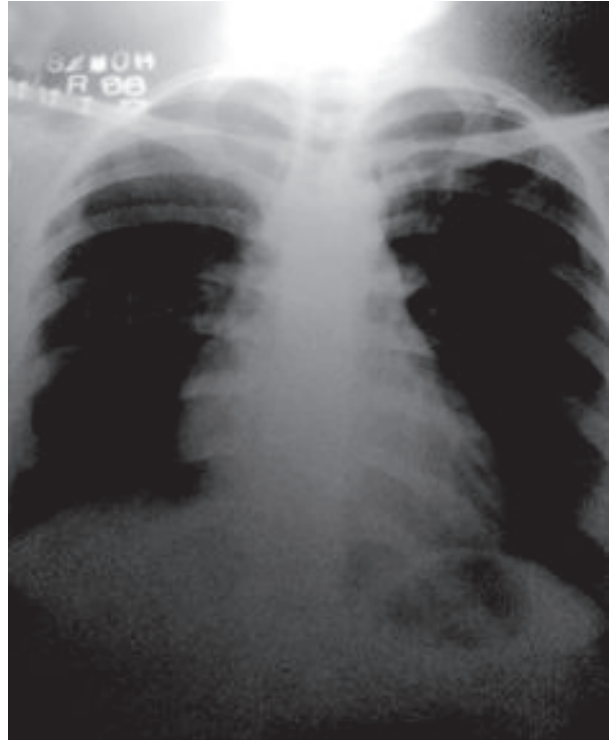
Chest X-ray before operation showing Right hilar mass (red arrow mark).
